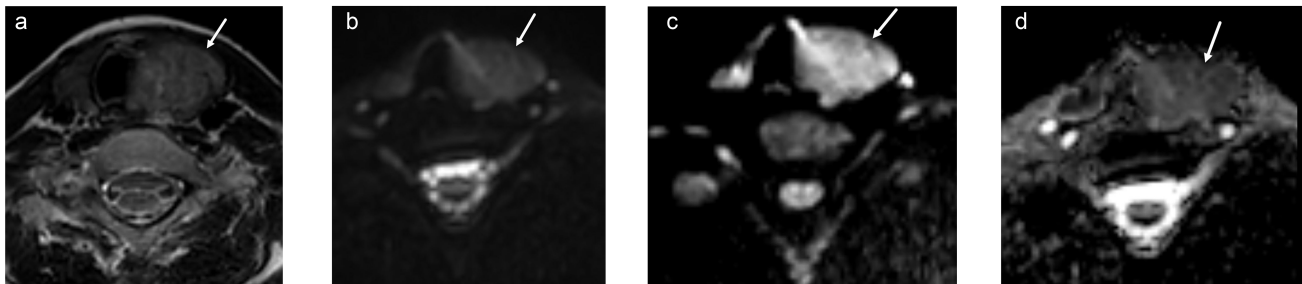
A 26-year-old female with a left thyroid nodule. On FNA biopsy, a follicular lesion of undetermined significance (Bethesda category IV) was reported. (A) T2-weighted image shows a nodule with intermediate signal intensity in the left lobe of the thyroid gland (arrow). The nodule-to-muscle T2-weighted signal intensity ratio is 3.03. (B,C) DWI images at b=0 and b=1000. (D) ADC map showing the thyroid nodule with an ADC value of 1.218 and nodule-to-spinal cord ADC ratio 0.924. The final surgical pathology was papillary thyroid carcinoma. FNA, fine-needle aspiration; ADC, apparent diffusion coefficient; DWI, diffusion-weighted images.
